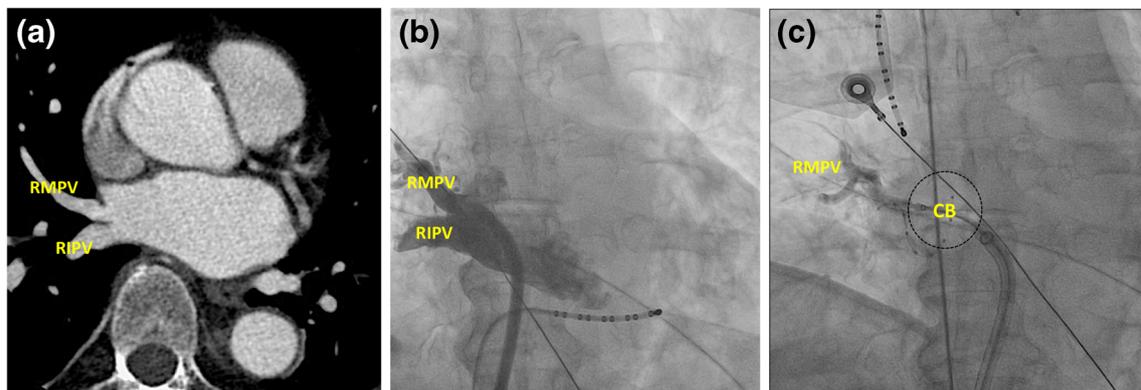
Example of a selective cryoballoon application to the RMPV. a Axial CT image of LA: the RMPV drainage is shown as a completely separated vessel from RSPV and RIPV. b AP fluoroscopic view with angiogram of the RMPV. c AP fluoroscopic view during a direct
